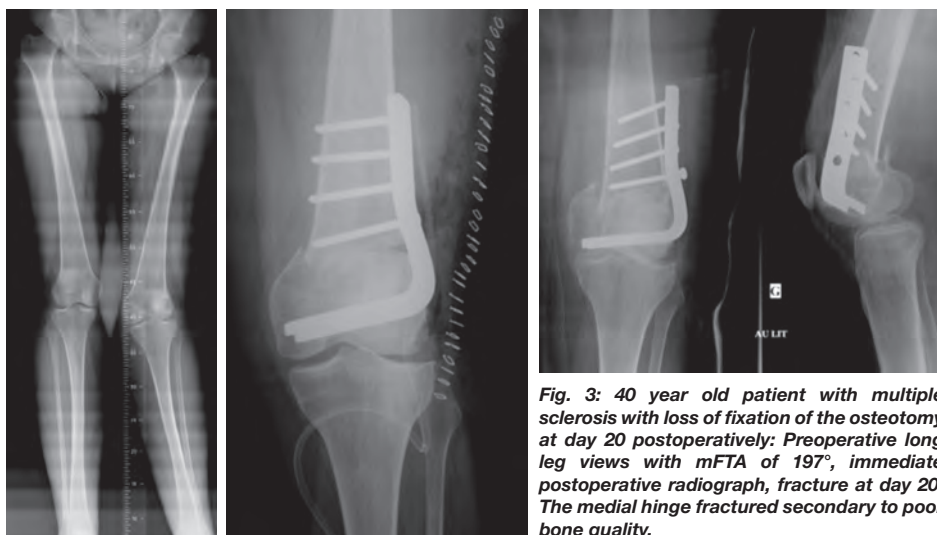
40 year old patient with multiple sclerosis with loss of fixation of the osteotomy at day 20 postoperatively: Preoperative long leg views with mFTA of 197°, immediate postoperative radiograph, fracture at day 20. The medial hinge fractured secondary to poor bone quality.
